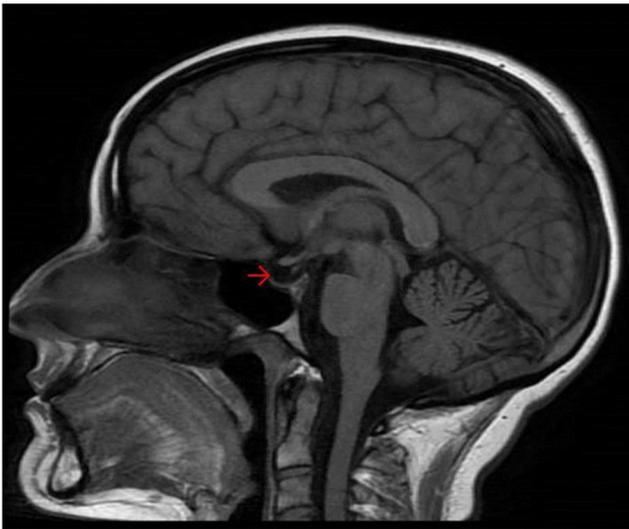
Pituitary MRI showing empty sella turcica resulting from pituitary infarction following traumatic brain injury (arrow)
